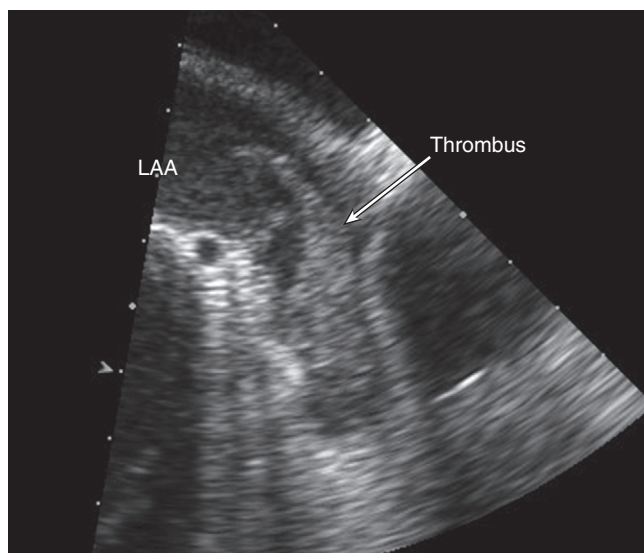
■ Imaged using transesophageal echocardiography, an atrial thrombus is seen in the left atrial appendage (arrow) in a patient with atrial fibrillation undergoing evaluation for elective cardioversion. Low-velocity blood flow is evidenced by the spontaneous echo contrast seen at the ostia of the left atrial appendage.
